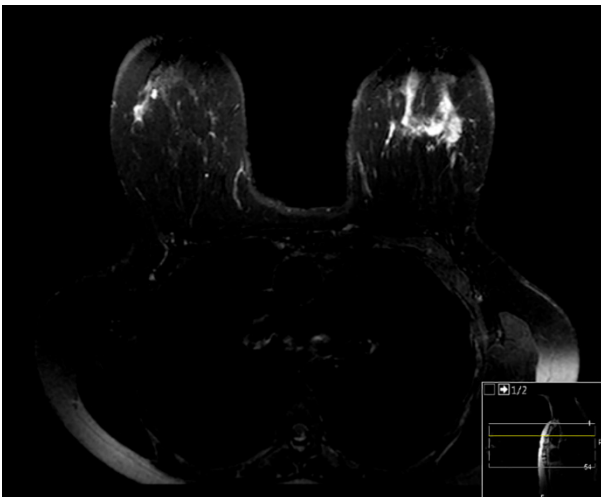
Breast MRI at diagnosis, using the SPAIR fat suppression technique
